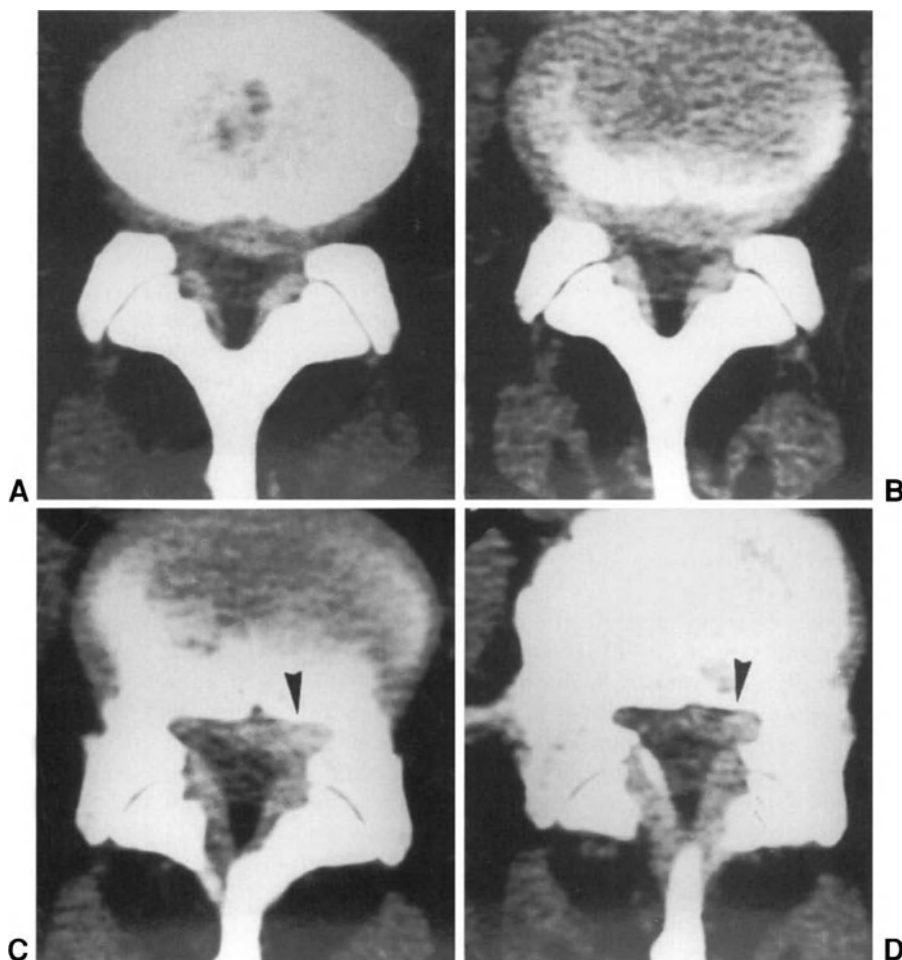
CT scans of a female with contained paramedian disc herniation who underwent manipulation (A) and (B). After four manipulations, radicular symptoms became more severe with onset of a L5 motor deficit. The patient withdrew from treatment. CT scans performed after the last manipulation (C) and (D) showed subligamentous extruded herniated disc (arrowheads).
